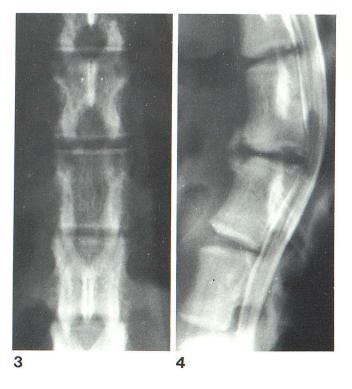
Posteroanterior radiograph of spine demonstrating L4 laminectomy. Fig. 4.—Lateral radiograph from metrizamide myelogram 4 months after laminectomy. Moderate kyphosis and anterior osteophytes have developed.
